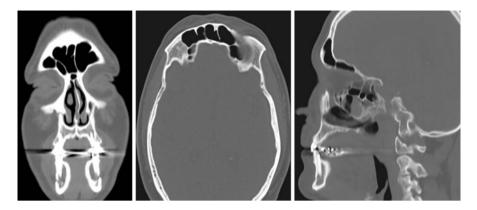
Coronal and triplanar CT imaging demonstrating the association of frontal septations with SOECs
